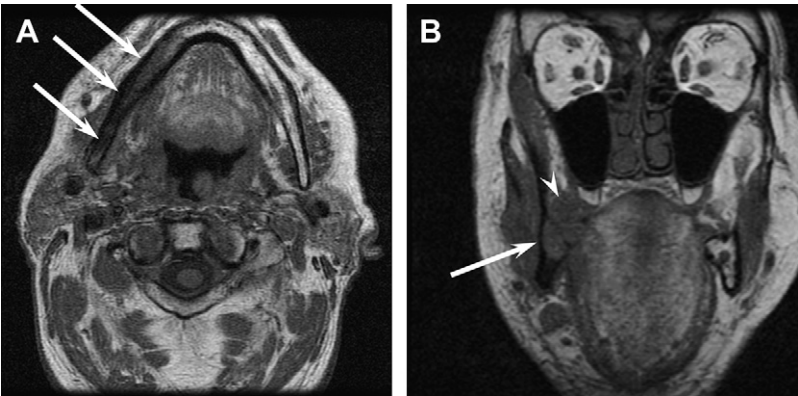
MRI for bone invasion. (A) Axial T1-weighted image shows asymmetric low signal (*arrows*) in the marrow of the right hemimandible. (B) Coronal T1-weighted image confirms abnormal low signal in the right hemimandible with cortical thinning (*arrow*) and soft tissue adjacent to the mandible (*arrowhead*). These findings confirm invasion of the mandible by squamous cell carcinoma.
